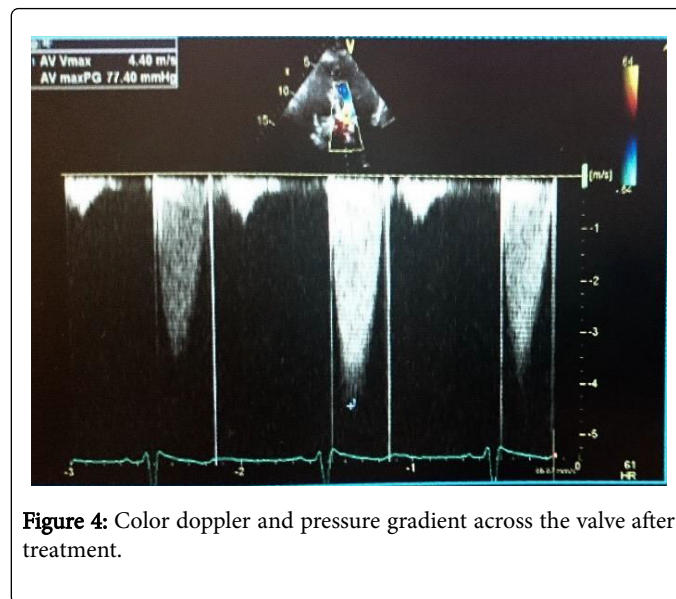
Color doppler and pressure gradient across the valve after treatment.
